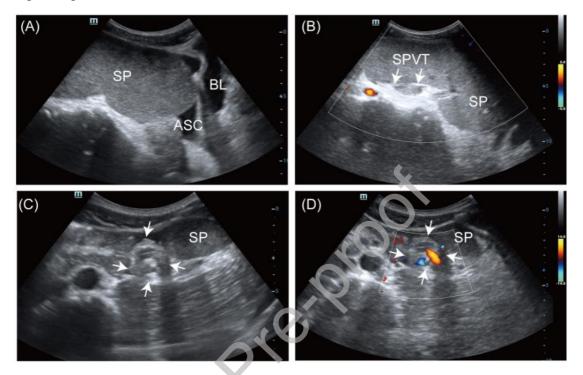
Ultrasonographic features of torsion of the wandering spleen. (A) An enlarged wandering spleen adjacent to the bladder was detected. (B) Color Doppler sonogram showed no color flow signal around or in the wandering spleen and splenic vein thrombosis. (C) A 'whirled sign' (white arrow) composed of splenic veins and arteries rotating around their axes was detected. (D) Color Doppler flow imaging revealed color flow signals in the 'whirled sign'. SP, spleen; ASC, ascites; BL, bladder; SPVT, splenic portal vein thrombosis.
